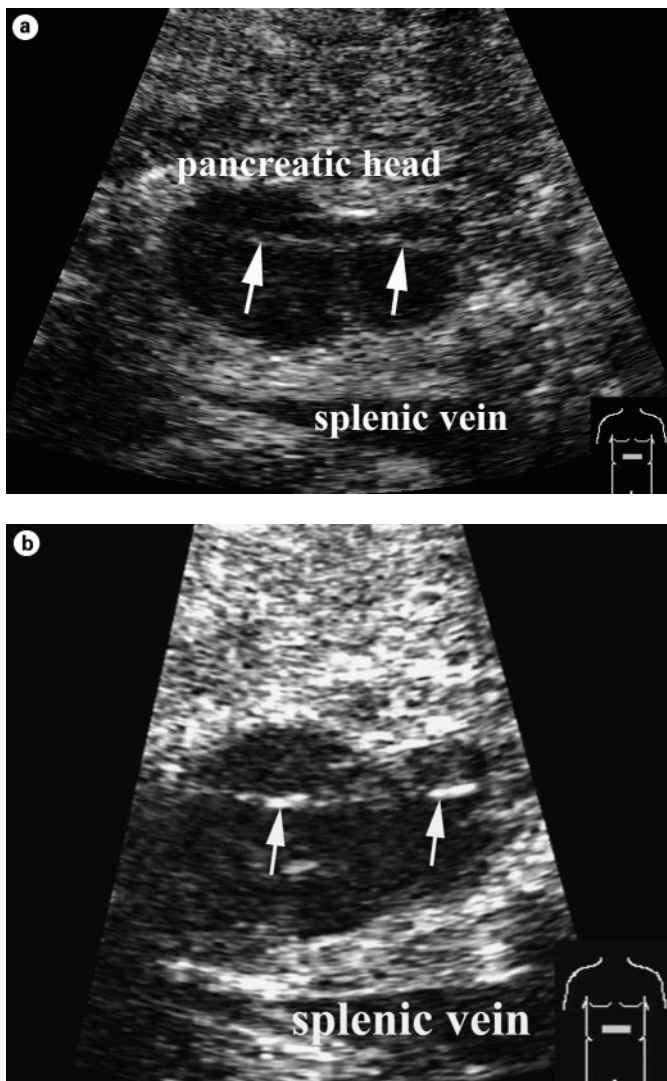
Cystadenoma at conventional (a) and echo-enhanced sonography (b). a Tumor (diameter 25 mm) with small cystic areas and thin fibrotic strands (arrows). b Highly vascularized tumor arteries along the fibrotic strands.
